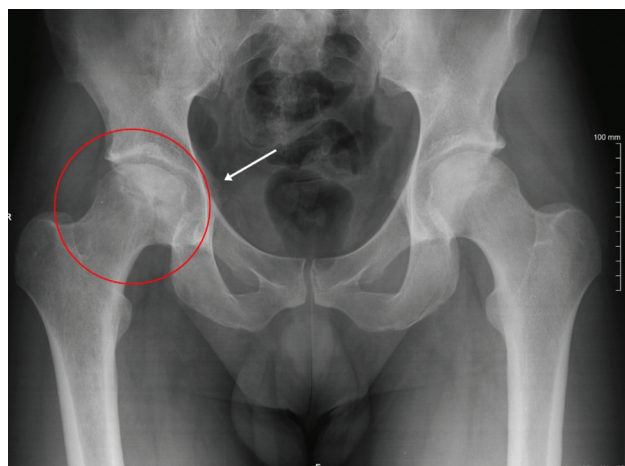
Radiographic image showing hip osteoarthritis
